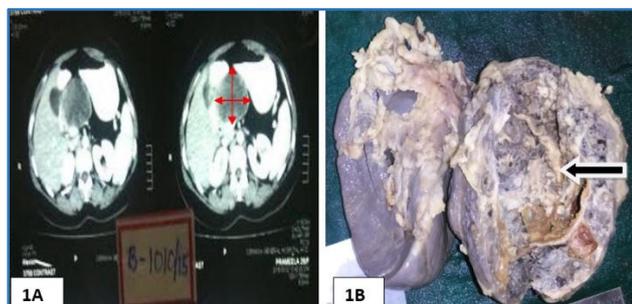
CT scan Imaging Depicting Tumour in the Head and Body of the Pancreas.
